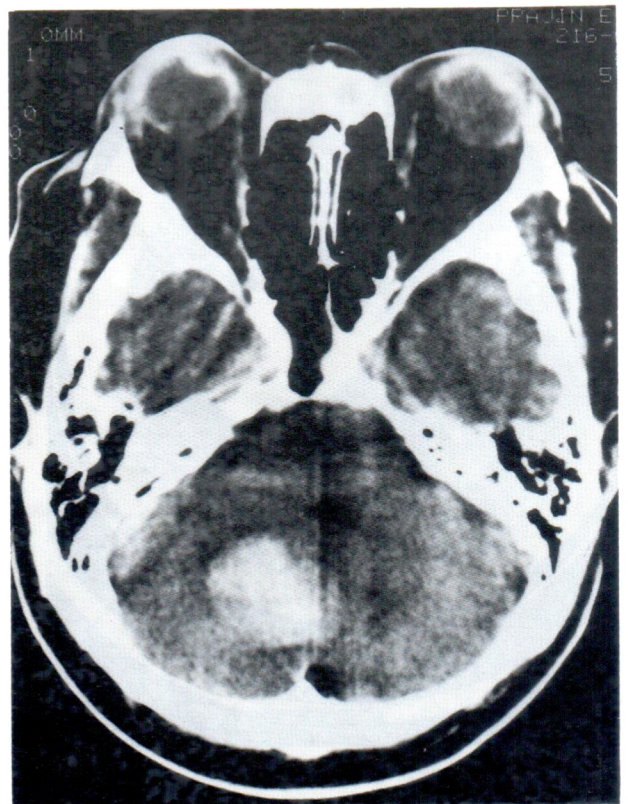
CT shows hematoma in right cerebellar hemisphere
